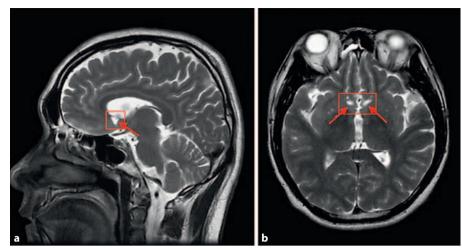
MRI sagittal (a) and horizontal (b) section demonstrates bilateral NAc lesions by T2-weighted images in 1 subject. Arrows show the target zones in the NAc.
